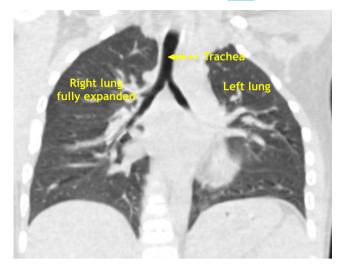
Postoperative coronal computed tomography image showing the normal lung parenchyma. (Image Credits: Dr. Viral B. Patel)
